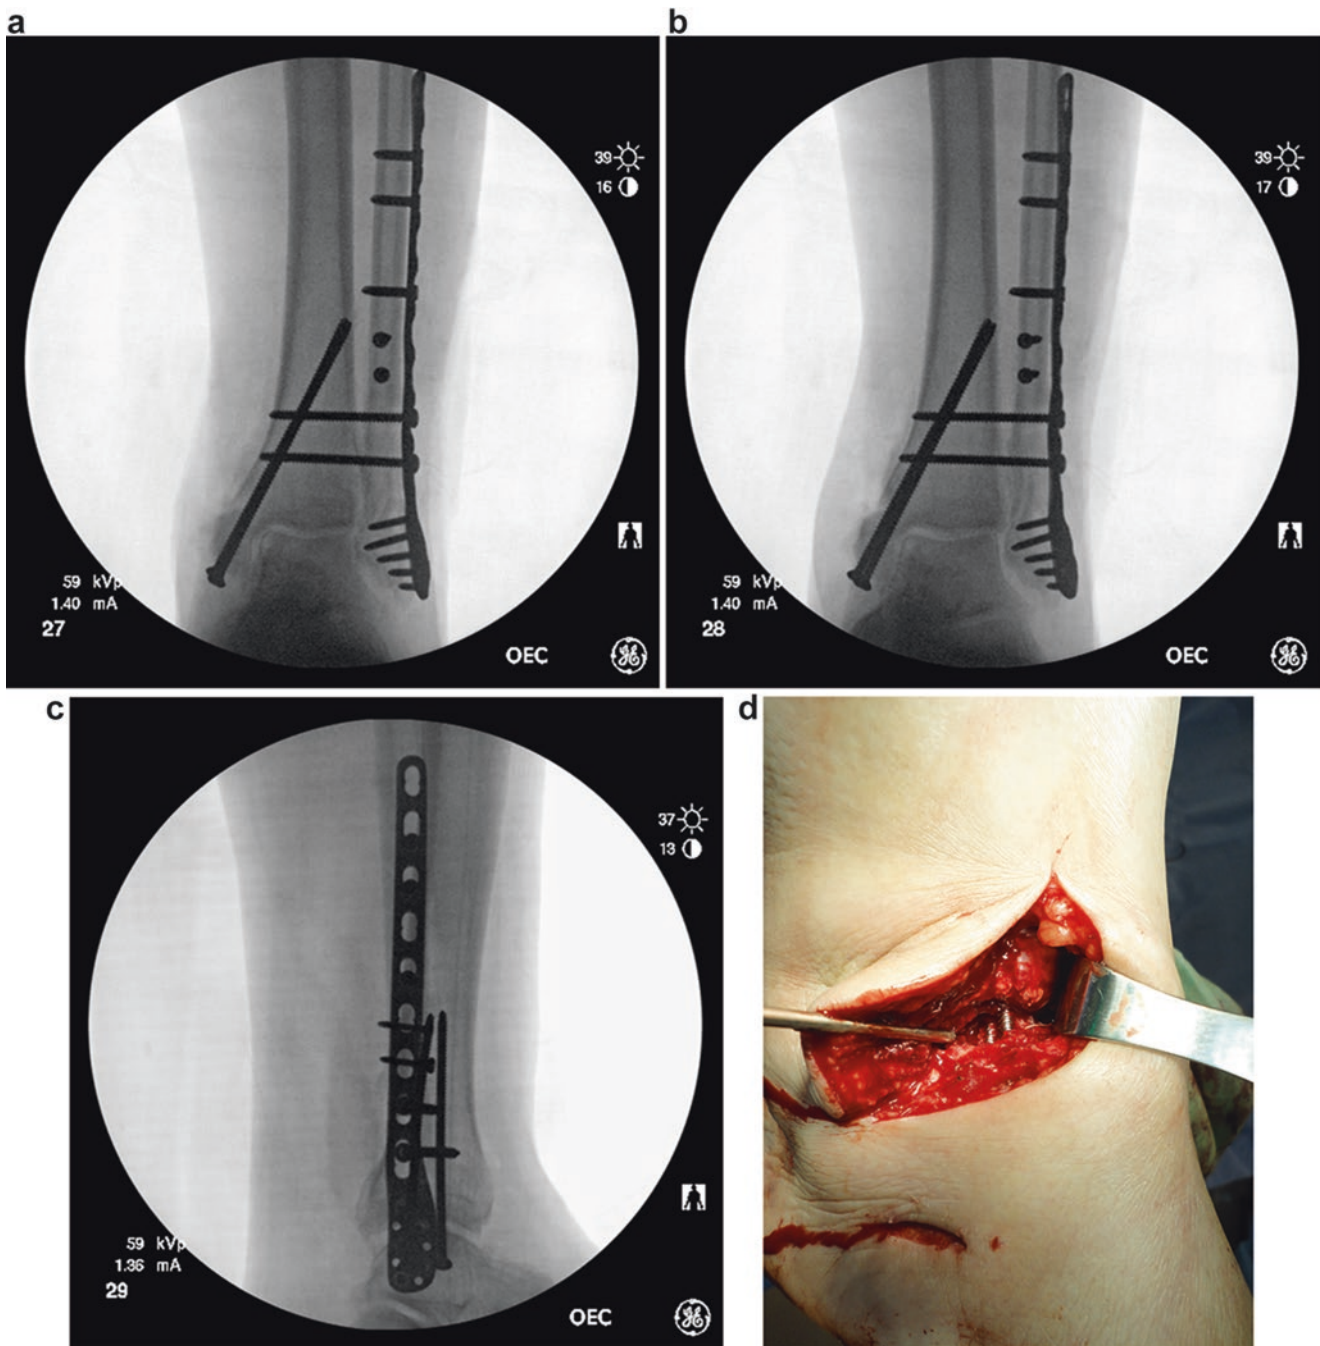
Anterior-posterior (a), mortise (b), and lateral (c) ankle intraoperative fluoroscopy demonstrating restoration of radiographic parameters. Intraoperative view of medial malleolar deficit and positional screws maintaining deformity correction after medial malleolar osteotomy (d)
